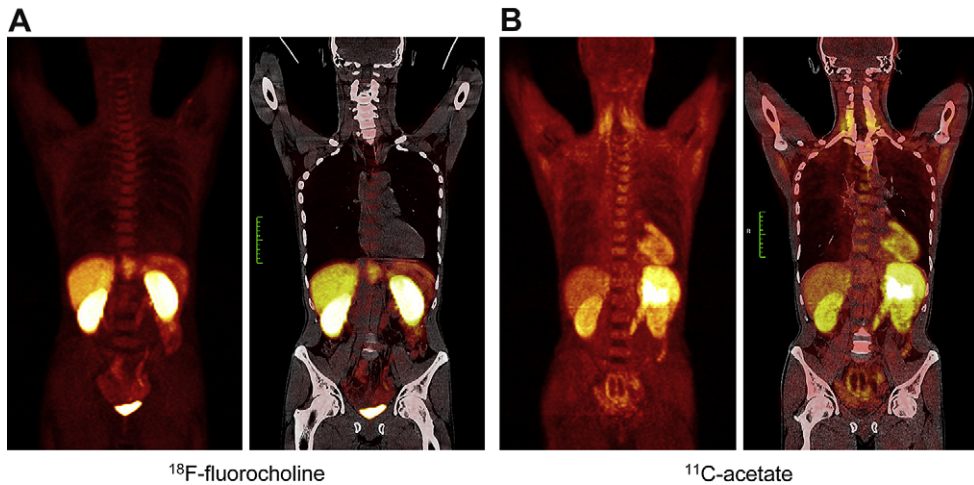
Role of PET/CT in novel tracer biodistribution studies showing typical biodistributions for ^{18}F -fluorocholine (A) and ^{11}C -acetate (B) in the same subject. The CT scan is used for attenuation correction of the PET data and for anatomic localization of tracer uptake and organ/tissue volumetric estimation which is required for dosimetry calculations.
